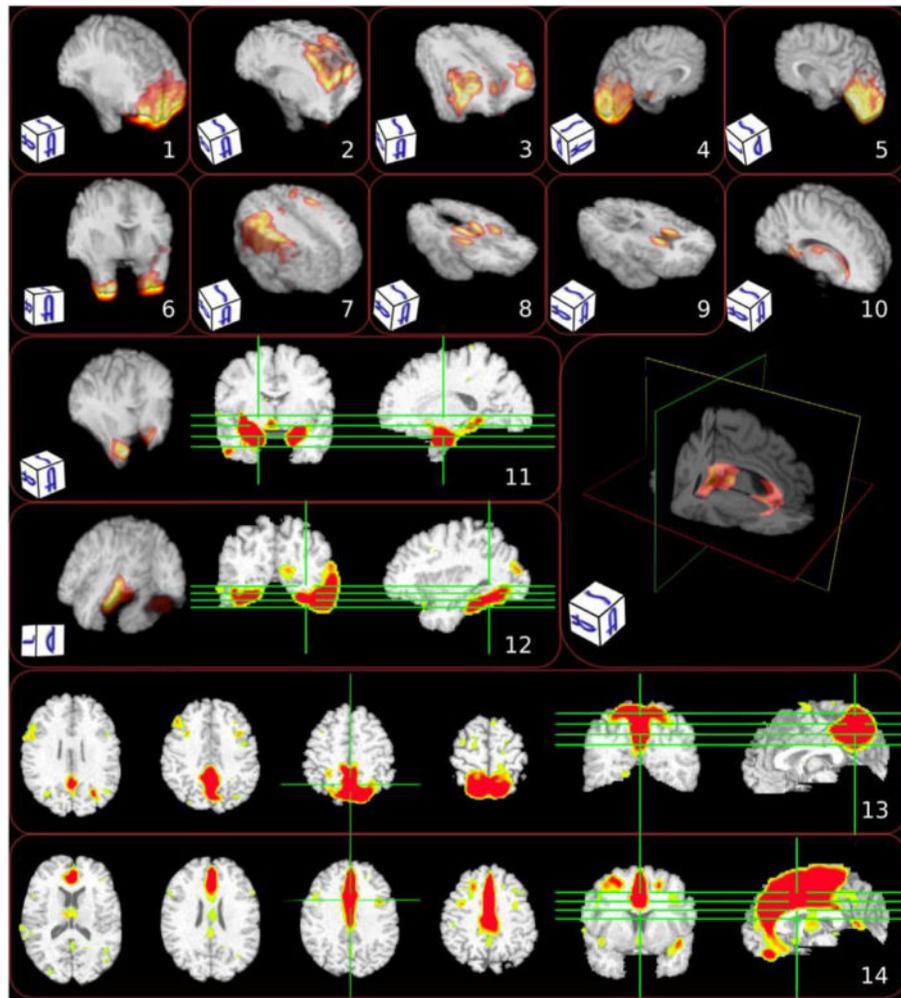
Components of structural co-variance identified via non-negative matrix factorization of structural MRI images reflect that a small number of anatomical units might be able to summarize high-dimensional imaging data in effective and highly interpretable ways. Figure reprinted from Sotiras et al. (2015).
